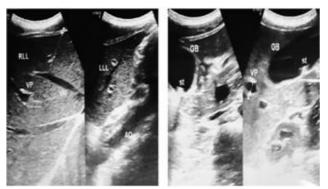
Repeated Abdominal Ultrasonography (Day 8).
